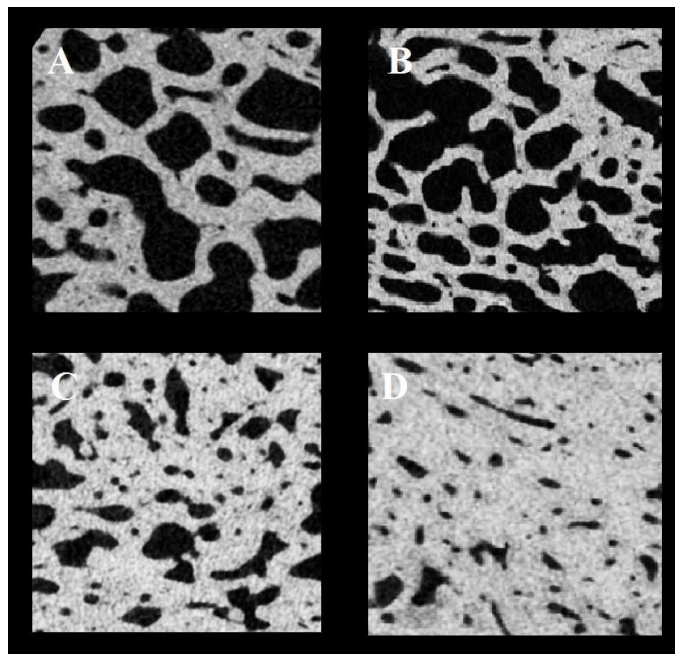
Cross-section micro-computed tomography images of the diploic region of the frontal bone in women demonstrating different macroscopic types (A, B, C and D) of HFI
